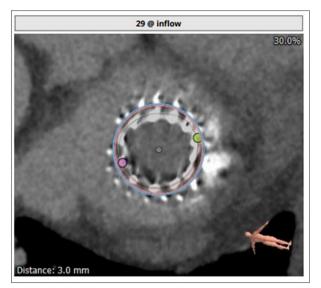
Computed tomography assessment of mitral valve: To assess annular size and to determine appropriate size of the new valve.
